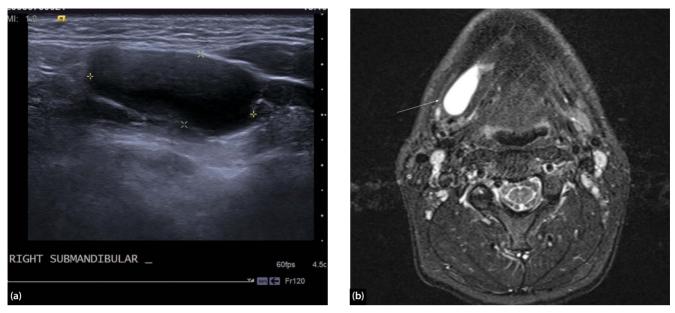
US (a) and axial STIR (short tau inversion recovery) MRI (b) of a cystic plunging ranula (white arrow) extending into the right submandibular space.
